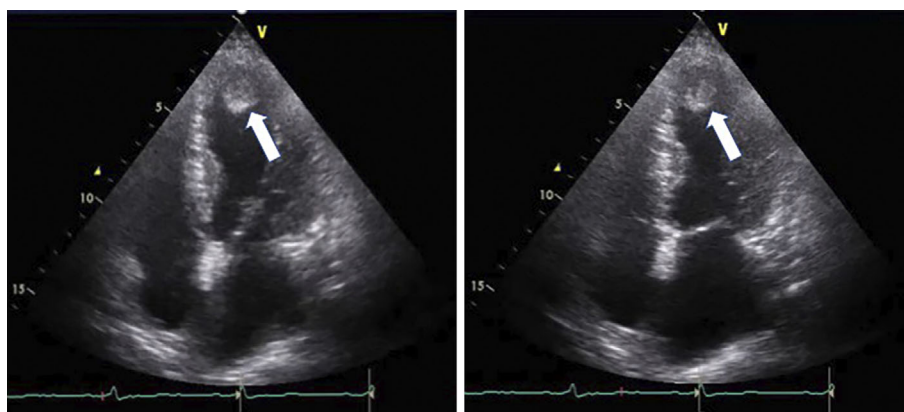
Transthoracic echocardiogram. Apical four-chamber view in end diastole (left side) and systole (right side) showing the thrombus in the apex of the left ventricle (arrow). Echocardiography revealed global left ventricular hypokinesia and no left ventricular hypertrophy.
